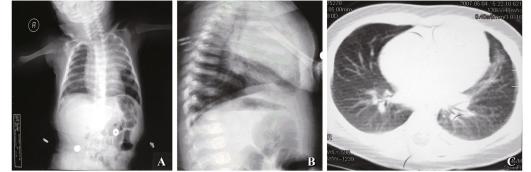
A: Plain chest radiograph demonstrating anterior mediastinal opacity; B: Lateral chest radiograph demonstrating anterior mediastinal opacity; C: A tuberculous mediastinal mass extending into the left lung.
